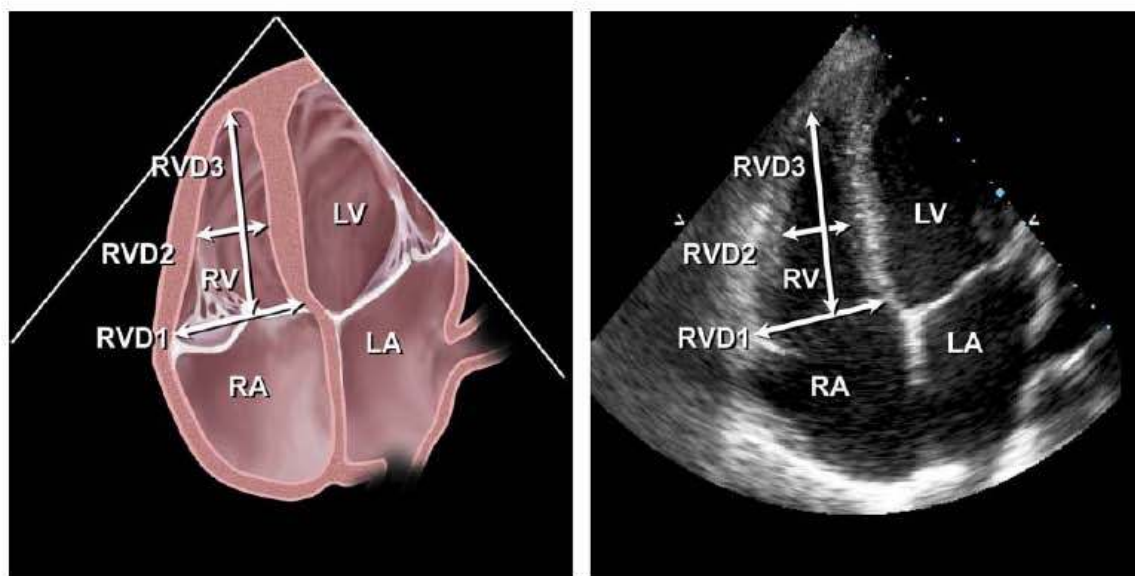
Mid right-ventricular diameter measured in the apical four-chamber view at level of left ventricular papillary muscles.
